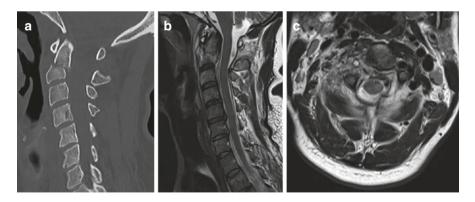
Preoperative imaging demonstrating an acute significantly comminuted, displaced type III Dens fracture with posterior displacement of fracture fragments into the central canal. (a) Sagittal CT (b) Sagittal T2-weighted MRI (c) Axial T2-weighted MRI
